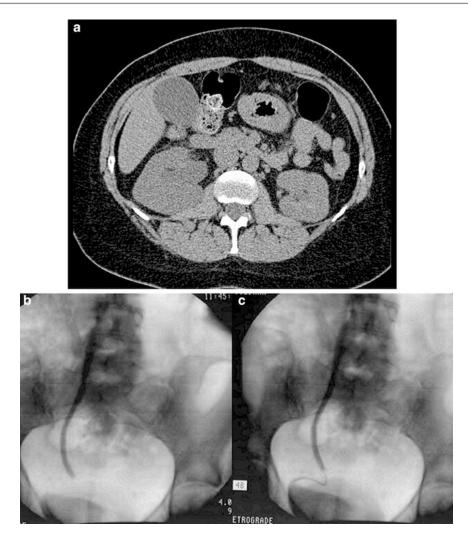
(a) A woman with postoperative suspicion of ureteral injury is found to have right hydronephrosis on a CT. (b) Right retrograde ureterography demonstrates medial deviation of the distal ureter, and the distal ureter
